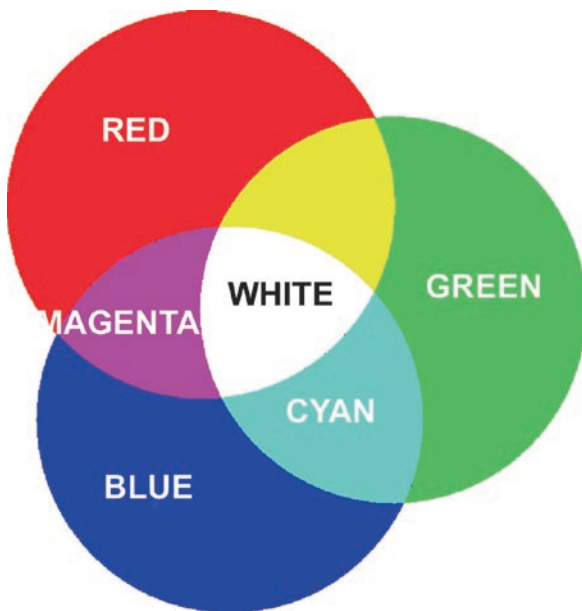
Colour-flow maps (based on combinations of red, blue, and green) are then constructed in which blood flow velocities are colour-coded in function of blood flow turbulence and direction. Blood flow towards the transducer (positive Doppler shift) is represented in red, while blood flow away from the transducer is observed in blue
